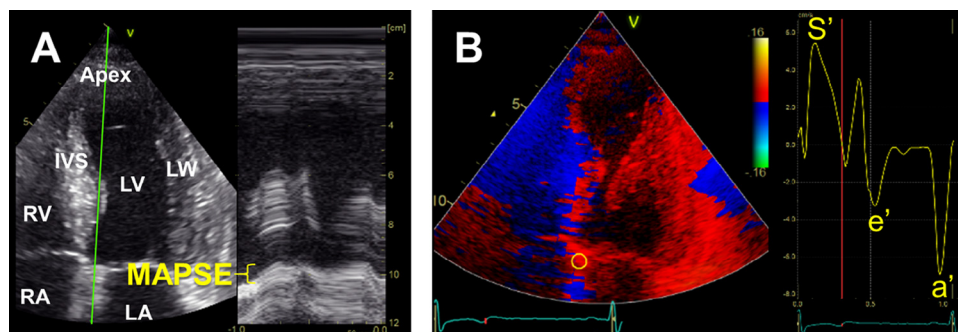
The acquisition of reference measurements of mitral annular motion indices. (a) The mitral annular plane systolic excursion (MAPSE) is here measured using anatomic M-mode on a B-mode apical four-chamber recording, revealing the left (LV) and right (RV) ventricles, the left (LA) and right (RA) atria, the apex, the interventricular septum (IVS) and the left ventricular lateral wall (LW). The principle is the same as for regular M-mode measurements. A virtual M-mode scan line (green) is pointed at the edge of the mitral annulus (here at the septal side), as seen to the left. The echo signal along this 1-D line during one cardiac cycle is seen to the right. A caliper is used to measure the displacement of the annulus during systole, which corresponds to the distance within the yellow, curly bracket. The same process is repeated at the lateral side. Septal and lateral measurements from three consecutive heart cycles are averaged. (b) The mitral annular velocities are measured from apical four-chamber color tissue Doppler recordings. A stationary 5×5 -mm sample volume is placed at the septal (yellow ring) and lateral (not marked here) sides of the annulus, as seen on the left. The septal tissue velocity curve from one cardiac cycle is seen on the right. The maximum positive velocity is the systolic peak velocity (S') and the maximum negative velocities are the early (e') and late (a') diastolic peak velocities. As for MAPSE, septal and lateral measurements from three consecutive heart cycles are averaged to calculate each index.
